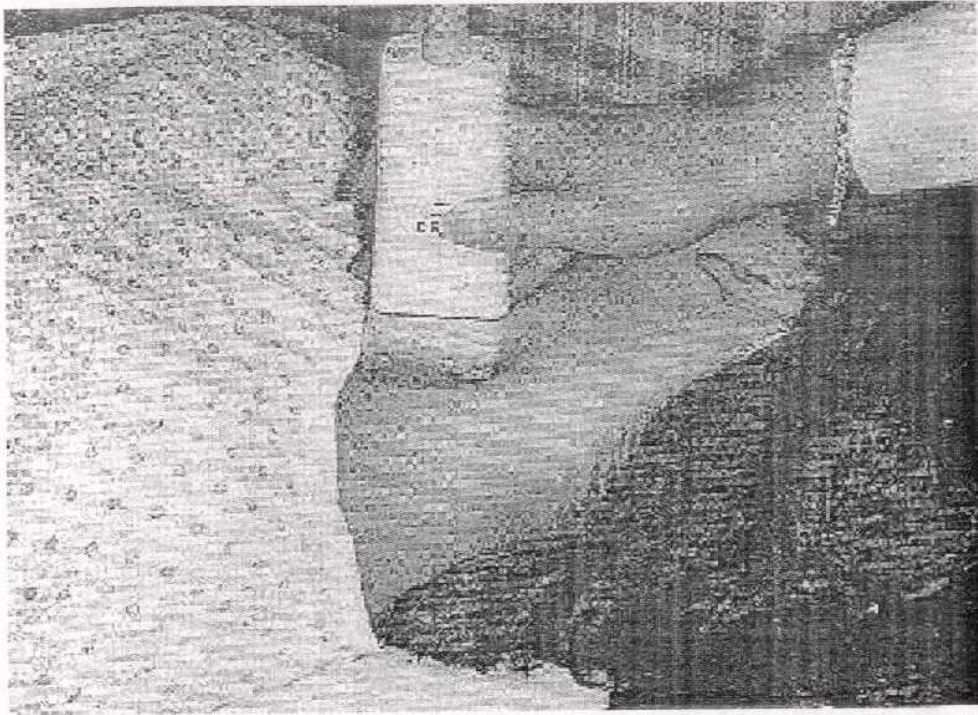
Transducer placement for Duplex scan-Doppler spectral evaluation of the vertebral artery (*Quoted from Diagnostic Ultrasound, 1998*).
